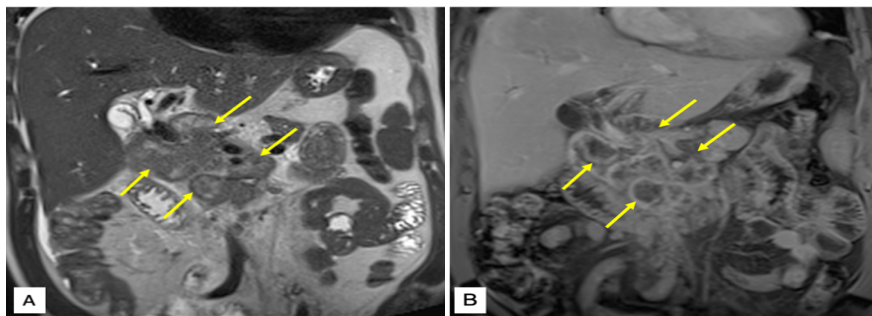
MRCP coronal views. (A) T2-weighted image. Multiple enlarged periportal and retroperitoneal lymph nodes showing peripheral enhancement and central area non-enhancing areas reflective of necrosis on post-contrast image (B).
